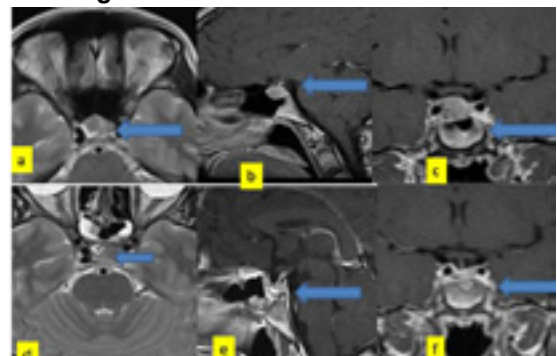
Postoperative MRI patient number (2) a: axial T2, b: sagittal T1 enhanced, c: control T1 enhanced, d: axial T2, e: sagittal T1 enhanced, f: control T1 enhanced MRI of pituitary gland showing the pituitary gland remnant after removal of the adenoma
